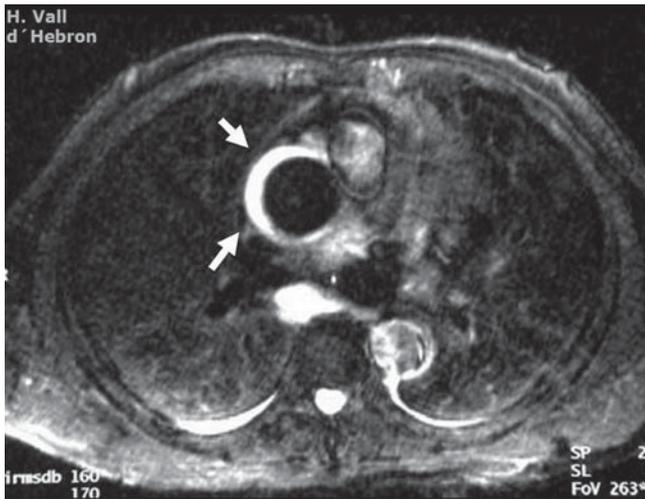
Type A intra-mural haematoma. Axial T1-weighted black-blood image shows thickening of the aortic wall with increased signal intensity (arrow)
